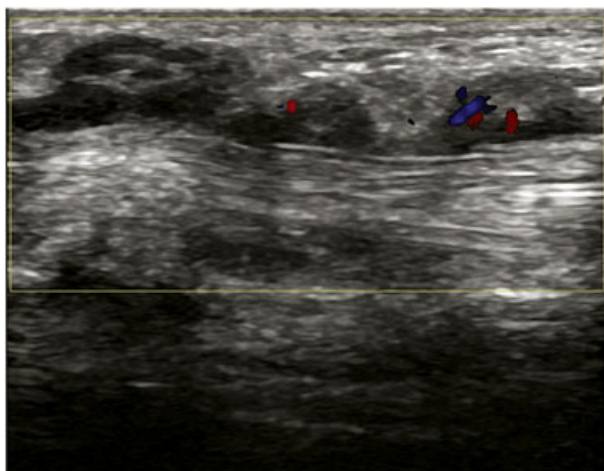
Colour Doppler imaging demonstrated an increase in internal vascularity of the solid mass.
